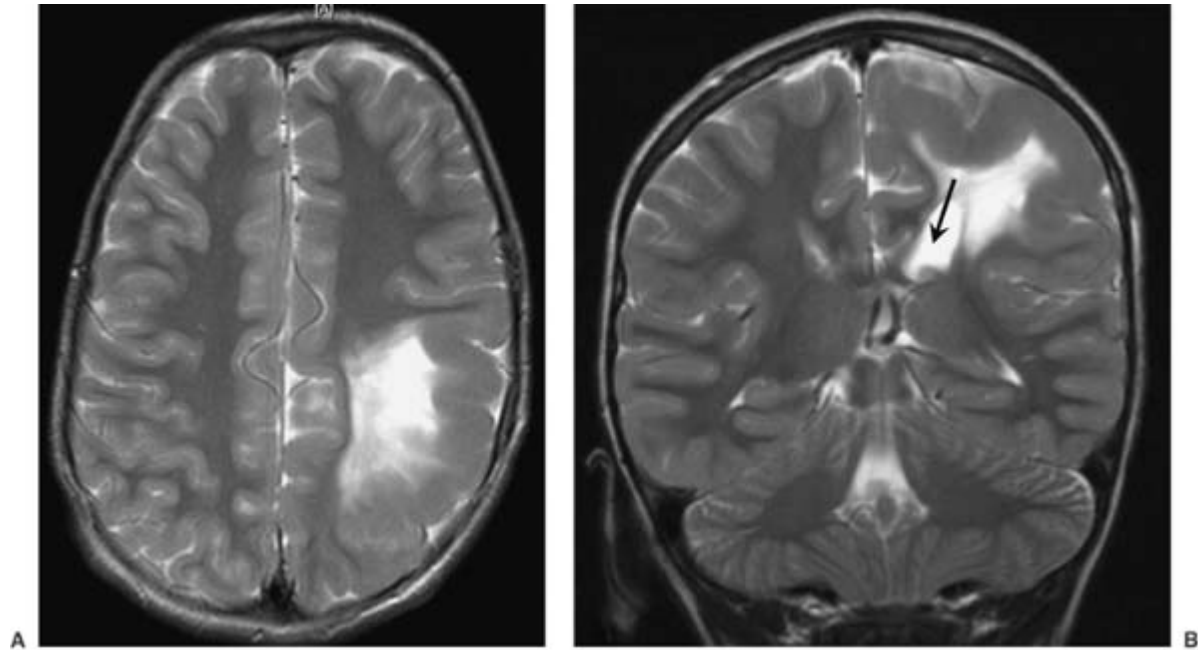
Focal cortical dysplasia extensively involving the left parietal lobe. T2-weighted axial (A) and coronal (B) images show thickened gyri and hyperintense signal in the white matter of the left parietal lobe. The left lateral ventricle is enlarged (*arrow*).
